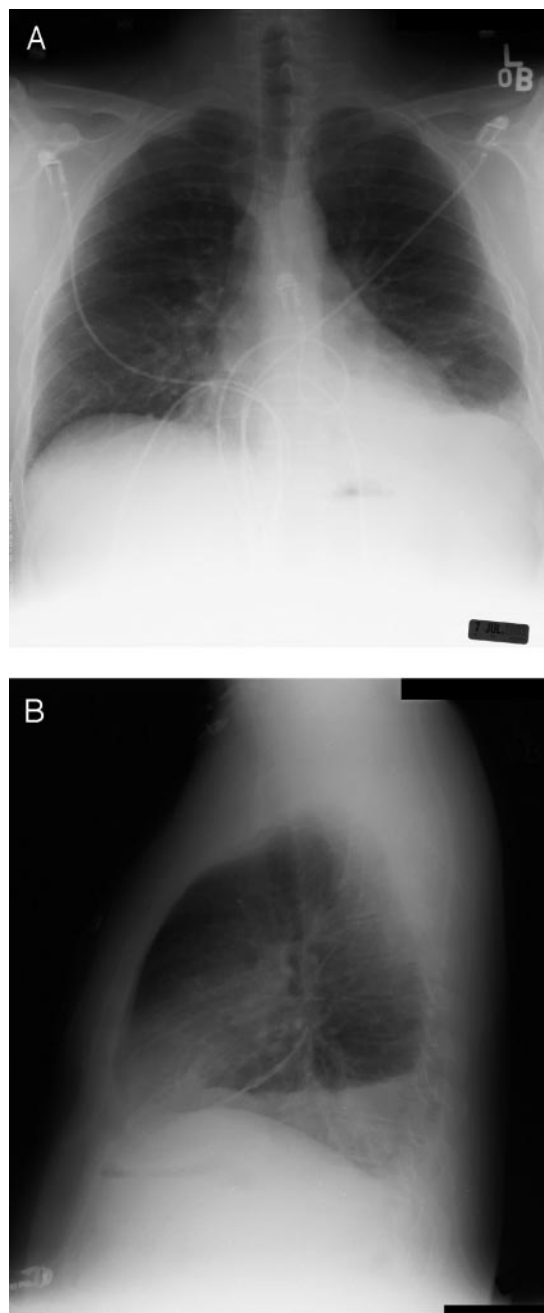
These posteroanterior (A) and lateral (B) chest radiographs show a small left pleural effusion and a streaky infiltrate in the lingula.
